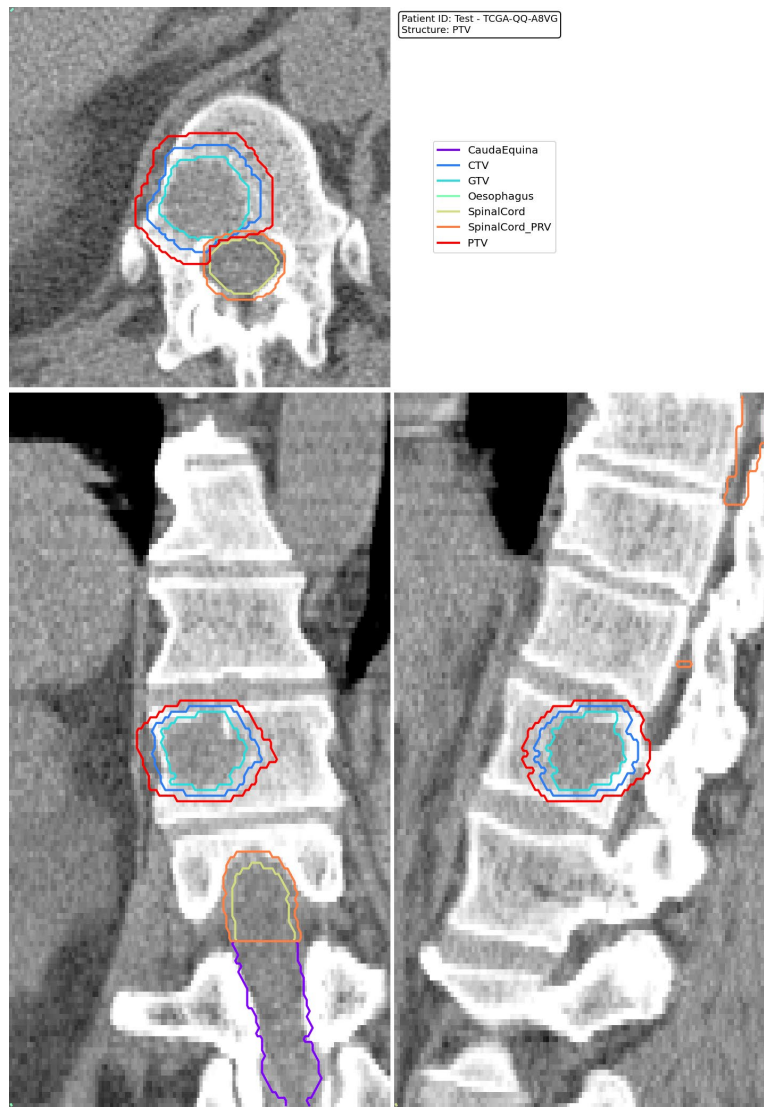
An example of the image produced for contour review. The ethics approval for this work does not allow images from study patients to be displayed. This CT image is taken from the Cancer Image Archive (193).
